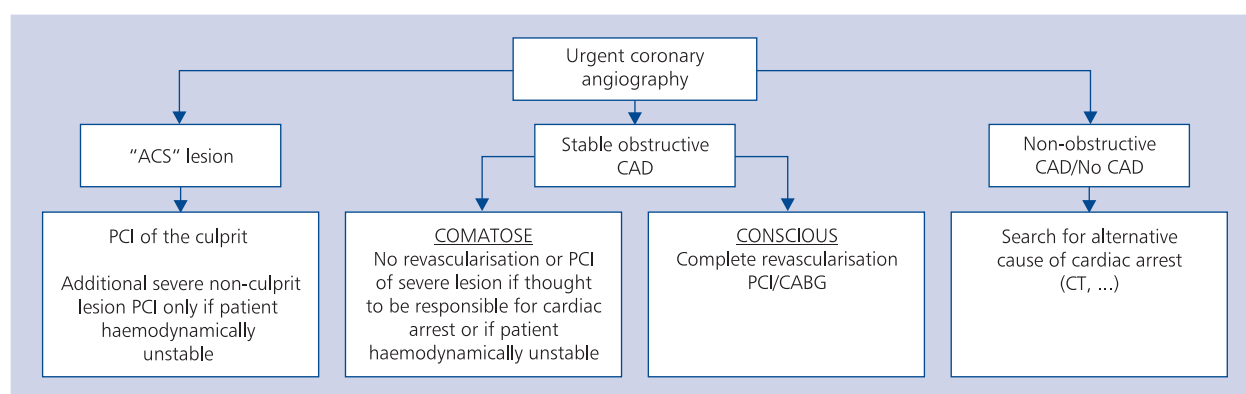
Revascularisation strategy after immediate coronary angiography in patients resuscitated from cardiac arrest at University Medical Centre, Ljubljana, Slovenia; ACS — acute coronary syndrome; CAD — coronary artery disease; CT — computed tomography; CABG — coronary artery bypass grafting; PCI — percutaneous coronary intervention [4]
